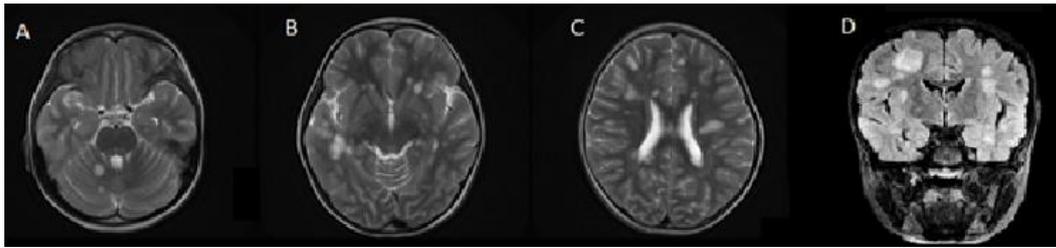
A, B, C, Axial T2-weighted image of brain magnetic resonance imaging (MRI), showing multiple hyperintensities. D, T2-FLAIR MRI shows multiple round lesions, seen as an increased signal.
